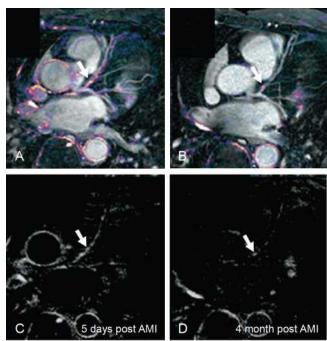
Coronary MRA of a 62-year-old patient with inferolateral infarction shows a luminal stenosis in the proximal left anterior descending (LAD) coronary artery (arrow) that corresponds to 50% stenosis in x-ray angiography (A) . MRA 5 days after infarction (C) shows contrast uptake within proximal LAD, MRA 4 months after MI (B. D) shows marked reduction of coronary enhancement in proximal LAD; the stenotic region shows mild uptake (arrow). A and B have fused images, which fused the enhancement in C and D with MRA. (Modified from Ibrahim T, Makowski M, Jankauskas A, et al: Serial contrast-enhanced cardiac MRI demonstrates regression of hyperenhancement within the coronary artery wall in patients after acute myocardial infarction. JACC Cardiovasc Imaging 2:580, 2009.)
